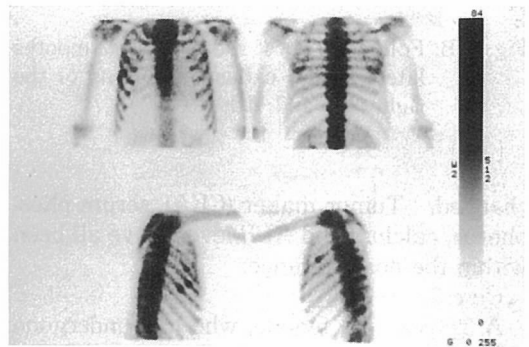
Bone scintigraphy showing abnormal accumulation corresponding only to the lesions seen on chest radiography. Lateral views revealed that the lesions were located in the axillary line. There were also abnormal accumulations in the adjacent above and below ribs.
